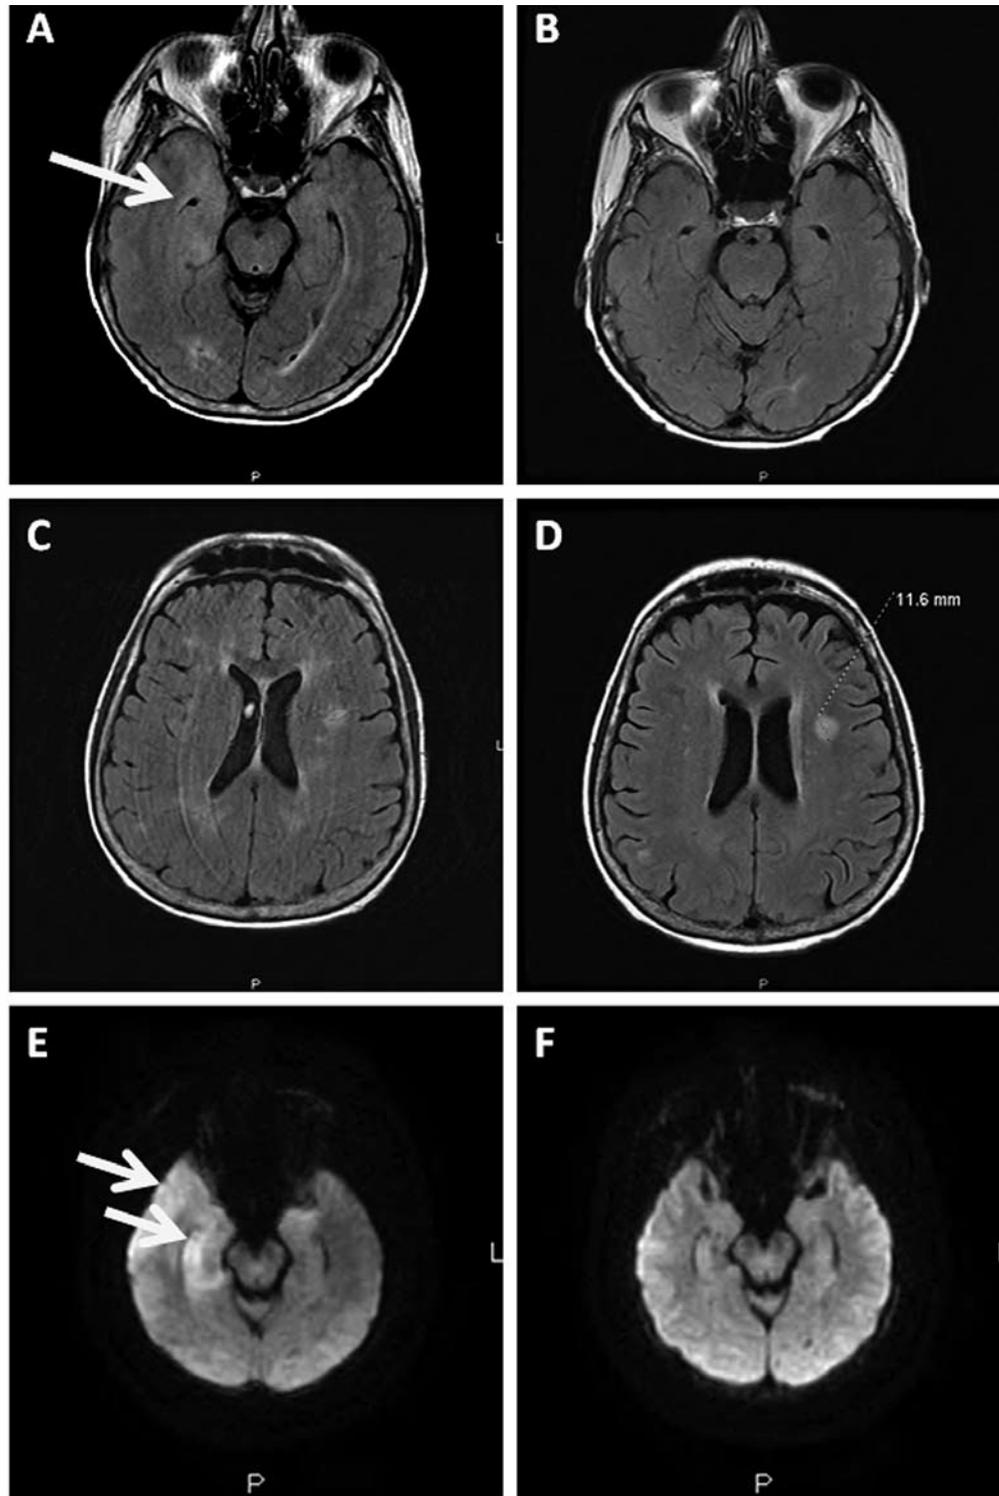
Magnetic resonance imaging (MRI) of the brain reveals changes of herpes encephalitis (HSE) and multiple sclerosis. A: T2 fluid attenuated inversion recovery (FLAIR) MRI of the brain showing areas of hyperintensity in the medial part of the right temporal lobe highly suspicious for herpes encephalitis. B: MRI taken one month prior to presentation reveals no evidence of enhancement on T2 FLAIR processed images in the temporal lobe. C: Hyperintense areas on T2 FLAIR MRI at presentation represent areas of demyelination suggestive of multiple sclerosis. D: MRI of the brain taken one month earlier shows the same lesions that remained unchanged during hospitalization for HSE. E: Diffusion-weighted axial images of the brain at presentation showing prominent enhancement of the right temporal region with a milder enhancement of the left medial temporal lobe. F: Diffusion-weighted axial images one month prior to diagnosis of HSE reveal no evidence of hyperintensity in the temporal lobes.
